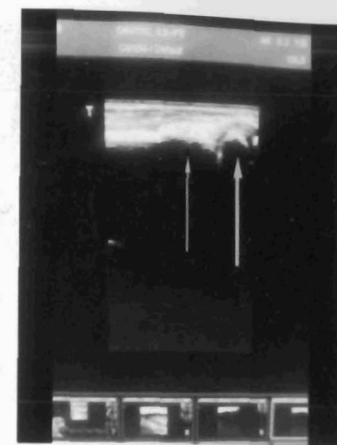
WEEK 6 HEALED SUPRACONDYLAR FRACTURE ULTRASOUND.
